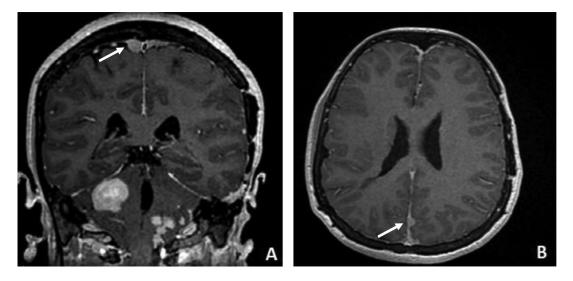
Coronal (A) and axial (B) T1-weighted contrast-enhanced MR images showing multiple dural-based homogeneous enhancing masses, suggesting the diagnosis hypothesis of multiple meningiomas (white arrows).
